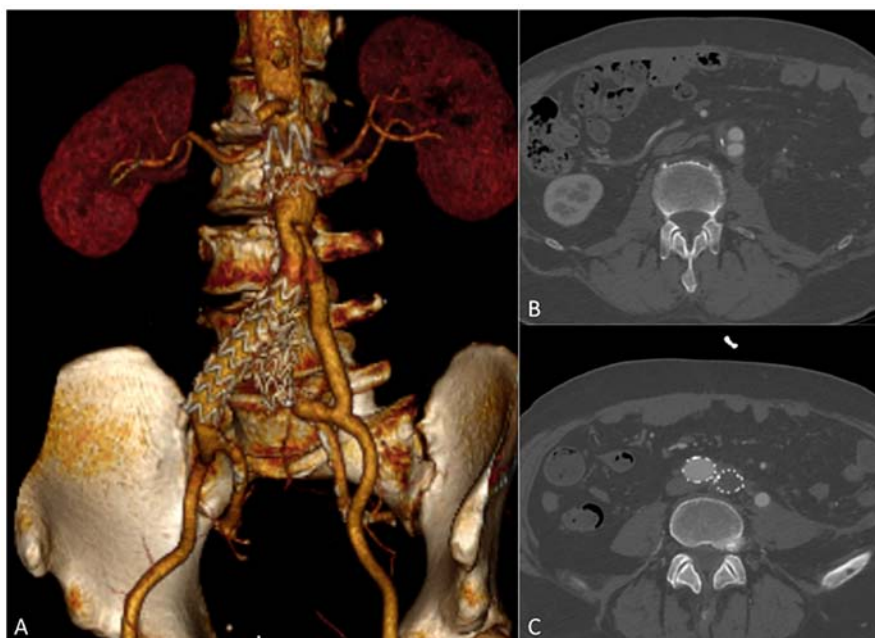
(A-C) Three-dimensional reconstruction of postoperative computed tomographic angiography underlying the aorto-bi-iliac reconstruction after the partial explantation of the stent-graft.
